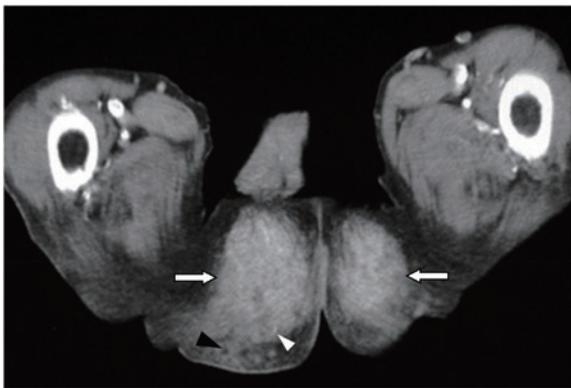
Contrast-enhanced CT at the level of the buttocks.
